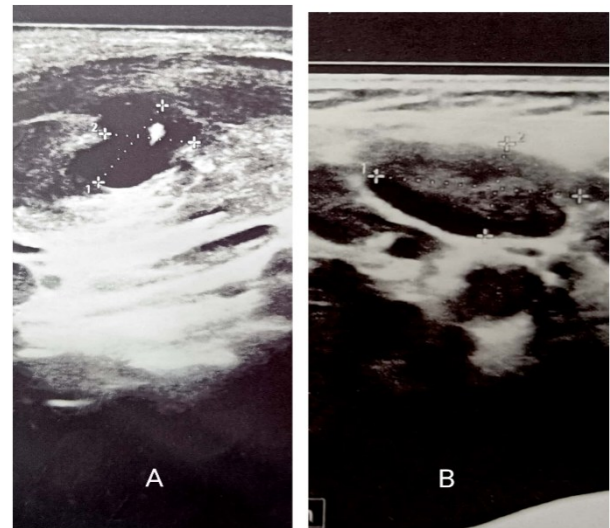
(A): Ultrasonography image of the patient at the time of presentation showing- abulky left sternocleidomastoid muscle with a 9 × 7 mm well-defined oval cyst containing a 2 mm echogenic focus likely representing calcification/scolex, no internal vascularity, and surrounding inflammatory changes: features suggestive of myocysticercosis of left Sternocleidomastoid
